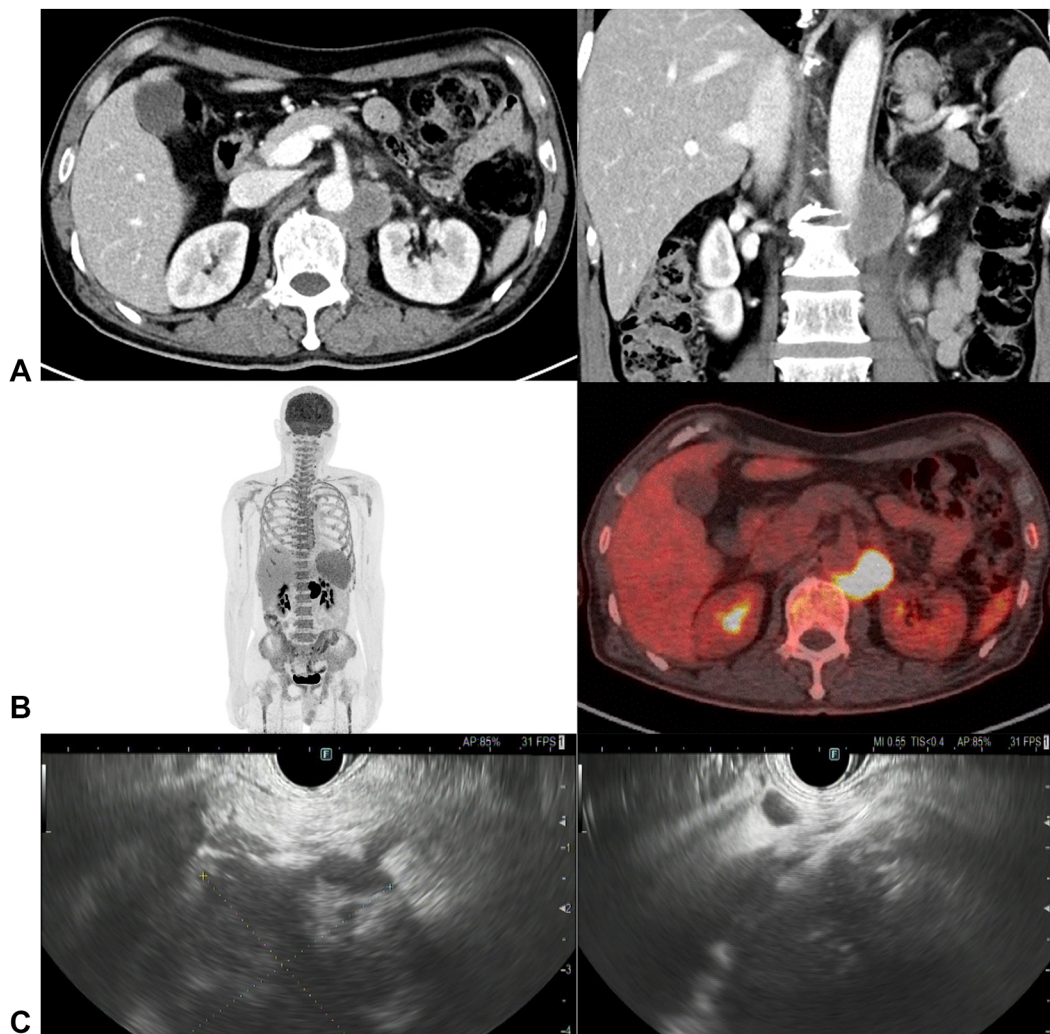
Representative images of target lymph nodes in suspected lymphoma. A, Contrast-enhanced CT showing bulky para-aortic lymphadenopathy. B, Positron emission tomography-CT showing fluorodeoxyglucose-avid mesenteric lymph nodes. C, EUS image of a hypoechoic lymph node during EUS-guided core biopsy using a 22-gauge needle.
